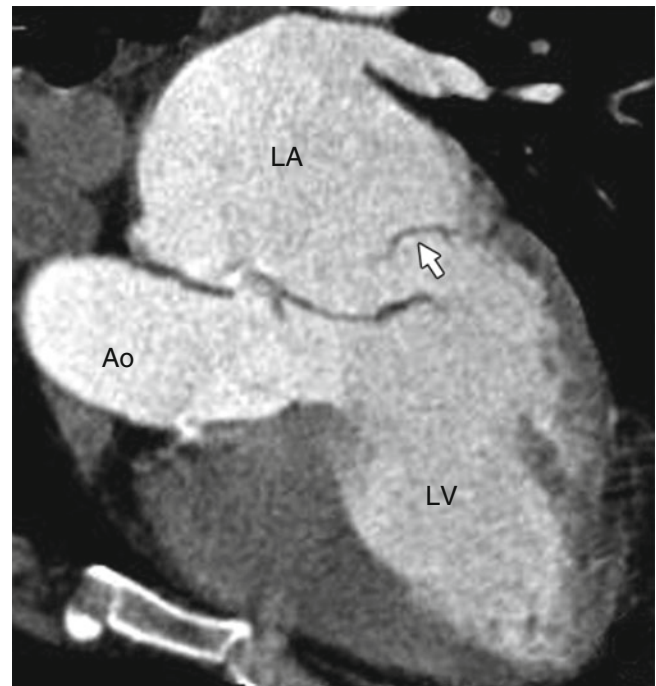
A computed tomographic example of a flail posterior leaflet (free-leaflet-edge prolapse, *arrow*). *LA* left atrium, *LV* left ventricle, *Ao* aorta (Reproduced from Feuchtner et al. [20]. With kind permission of Radiological Society of North America, Oak Brook IL)
